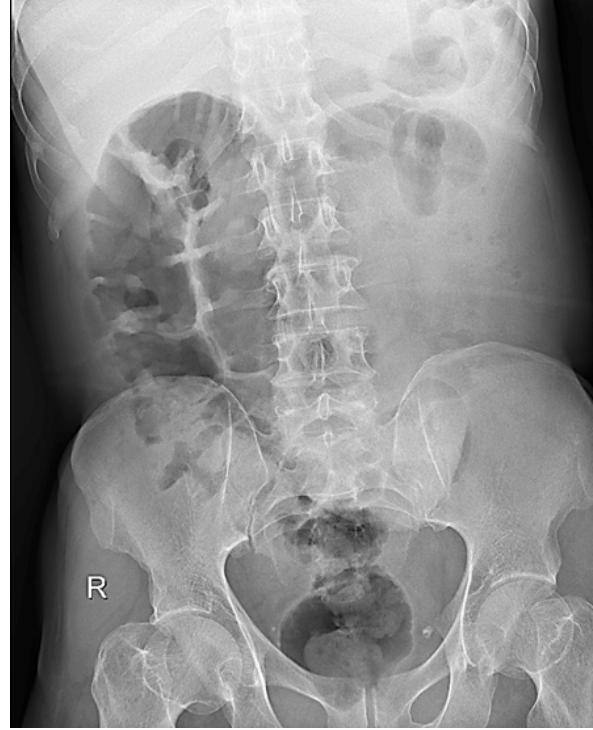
Abdominal X-ray (AP view): The arrow shows a dilated bowel loop.
